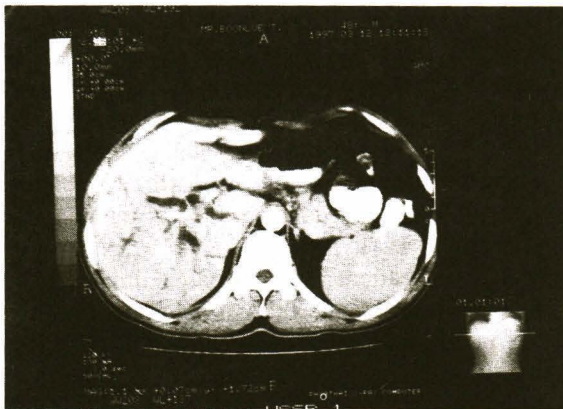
CT Scan shows obstruction of the common hepatic duct with dilatation of the intrahepatic bile duct.
